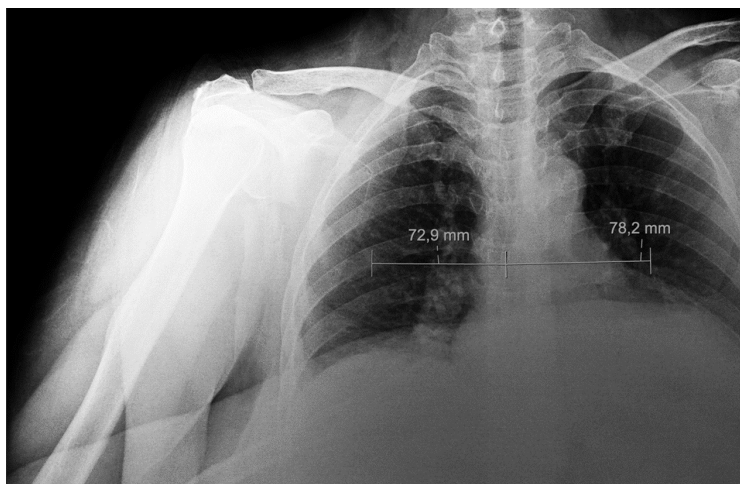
This is an AP radiograph of a 49-year-old female patient who has a scapula fracture.
